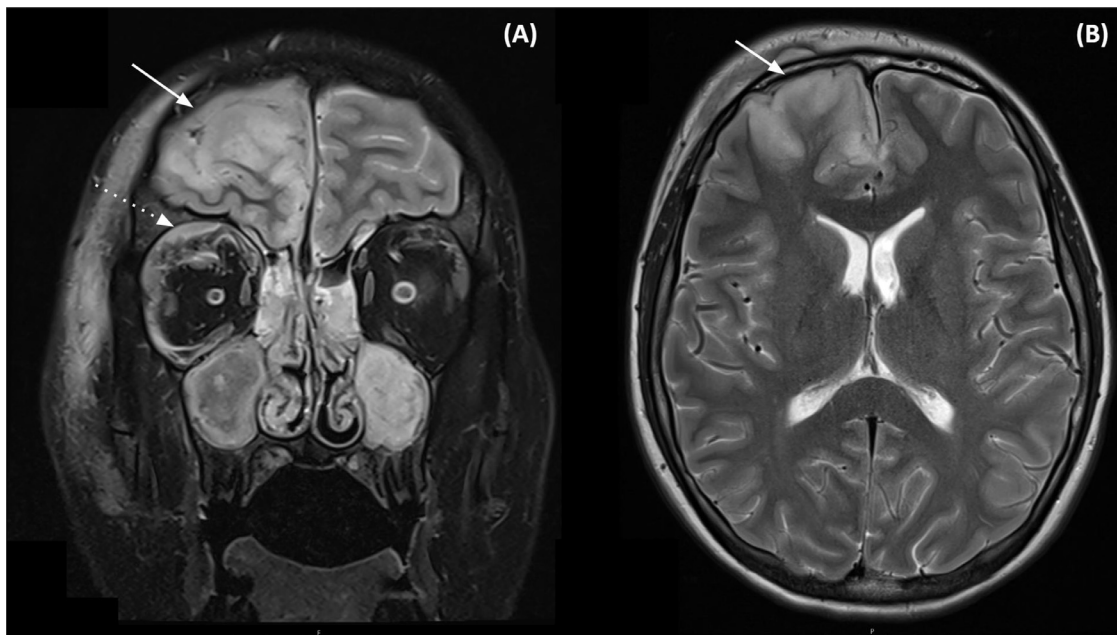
Initial MRI Brain with (A) T2 DIXON coronal plane showing areas of subperiosteal collection of the right orbit (Dotted white arrow) and corresponding areas of right frontal lobe cerebritis (Solid white arrow). Note of bilateral diffuse sinusitis with extensive opacification and mucosal enhancement. (B) T2 Axial plane with areas of right frontal cortical and subcortical T2 hyperintense area with mass effect and vasogenic oedema (Solid white arrow).
